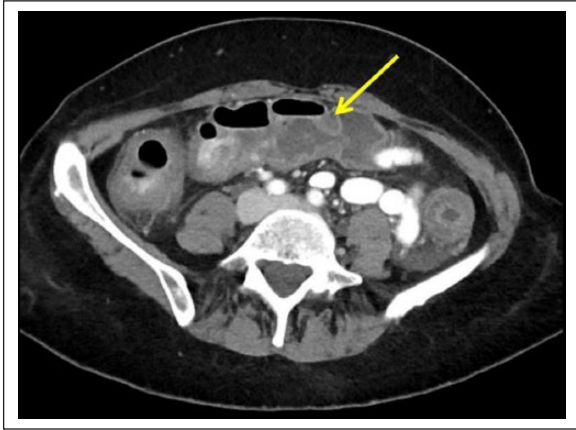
Diffuse colitis seen on computed tomography image (arrow).
